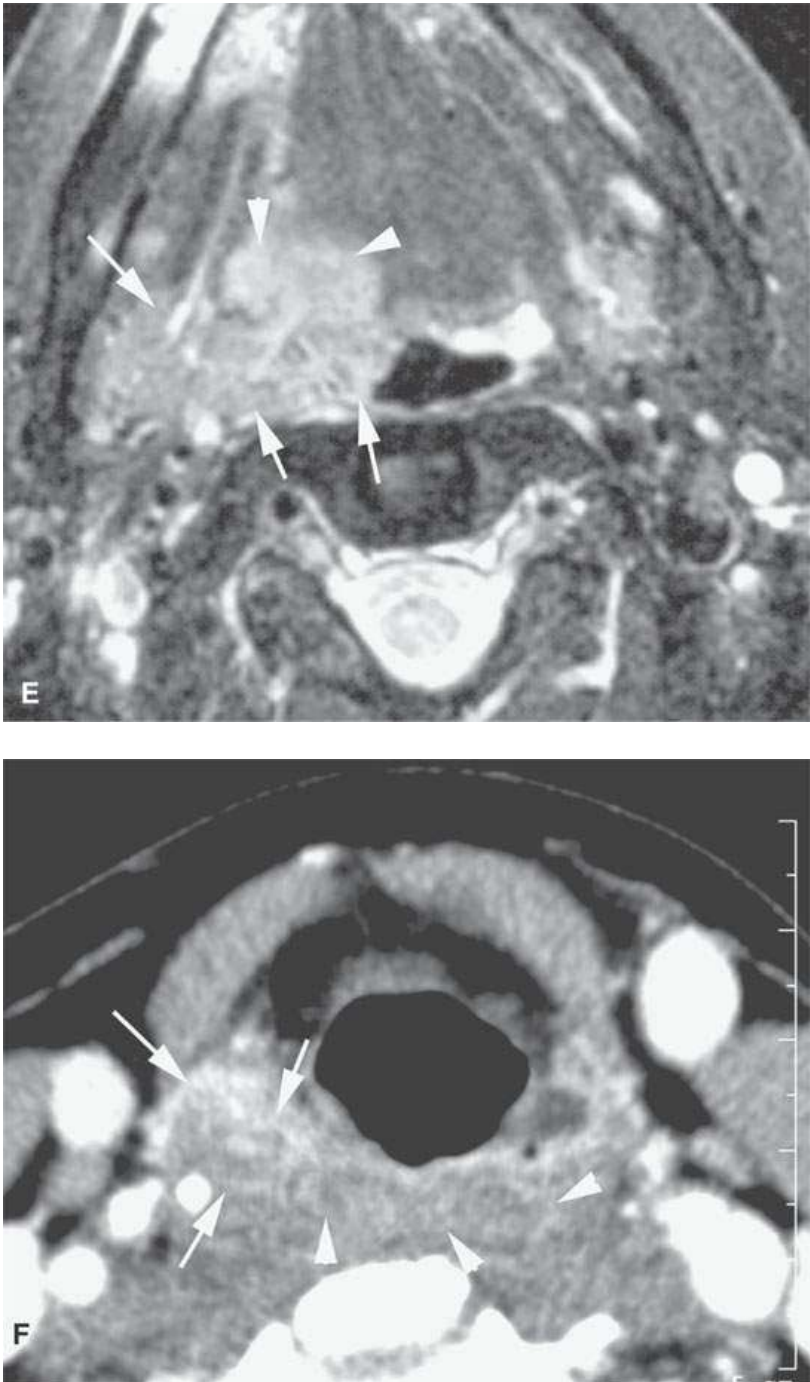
Four patients with squamous cell carcinoma and zones of tumor-related edema. None had a recent deep biopsy, and none had therapy. In all images, the *arrows* show the gross margins of the tumor, and *arrowheads* indicate zones of likely predominantly reactive edema (see text for the limit of reliability of such assumptions). A, B: Contrast-enhanced computed tomography (CECT) of a patient with oral tongue cancer with a relatively small primary and large zone of predominantly edema. C, D: CECT of a patient with posterior pharyngeal wall cancer with related pharyngeal wall and retropharyngeal space edema. E: Fat-suppressed T2-weighted images showing exophytic tumor with likely deep edema perhaps mixed with tumor. F: CECT of a relatively small pyriform sinus primary with marked posterior pharyngeal wall and retropharyngeal space edema.
